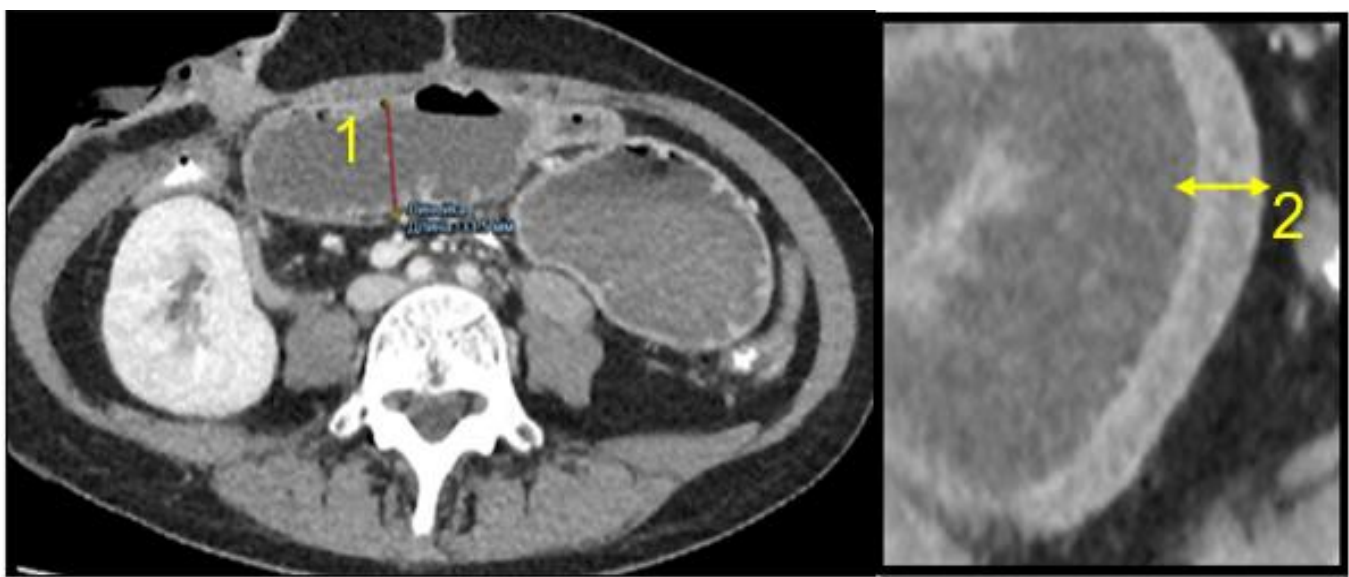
CT scans of abdominal organs: 1 – dilation of the loops of the small intestine up to 35 mm; 2 – thickening of the walls of the adductor small intestine up to 0.8 mm.
